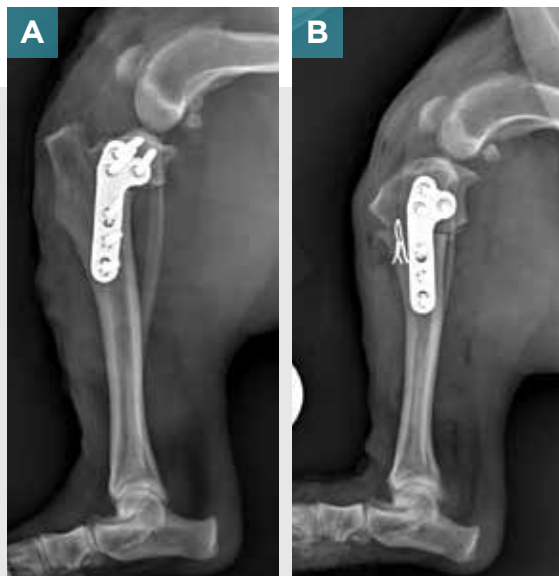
Postoperative radiographs in a bichon frise. The preoperative tibial plateau angle (TPA) was 37° on both sides. (A) Right stifle after tibial plateau leveling osteotomy (TPLO). The postoperative TPA is 8°. (B) Left stifle after cranial closing wedge (CCW). The postoperative TPA is 5°. Note that the CCW provides a more physiologic proximal tibia than the TPLO in this excessive TPA case.
